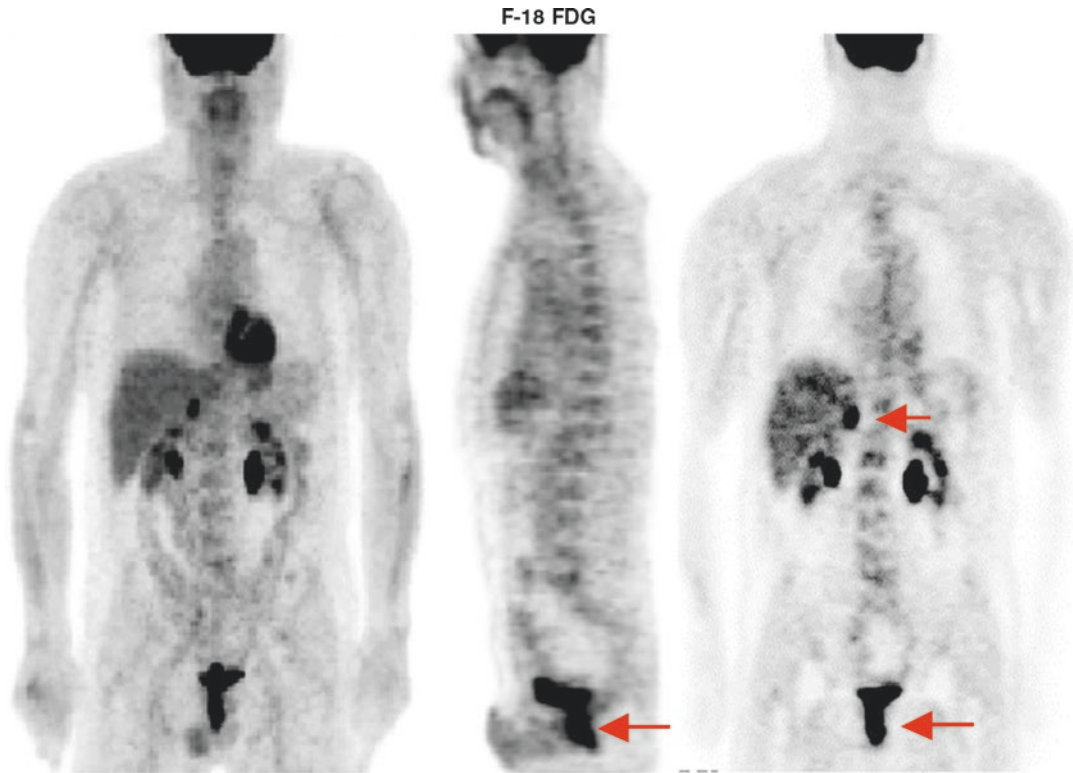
F-18 FDG study of a patient who had rising CEA 5 years after resection of rectal adenocarcinoma. MRI and CT were inconclusive. Five biopsies were
